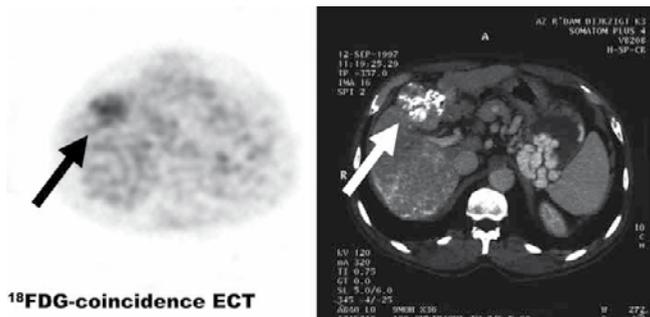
FDG coincidence ECT image (transverse) of a patient with HCC (Left), with corresponding contrast-enhanced CT image (Right). The tumor is indicated by arrows.
